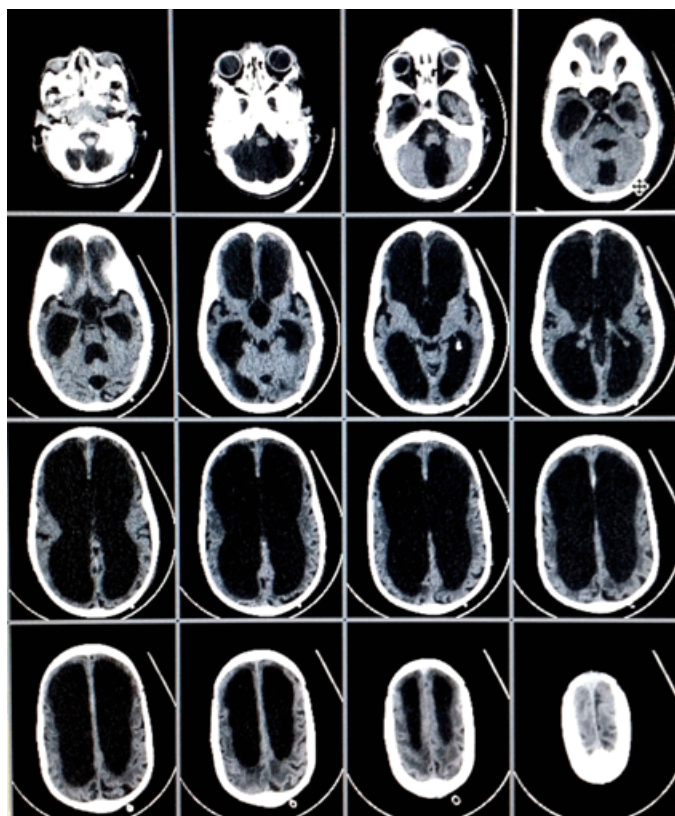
Axial non-enhanced computed tomography scan of the head of the patient demonstrating 16 sections of the brain at various levels. Note the extent of the dilatations of the ventricles with severe atrophy of the brain. Sulci look normal which give an idea about the intracranial pressure status.
